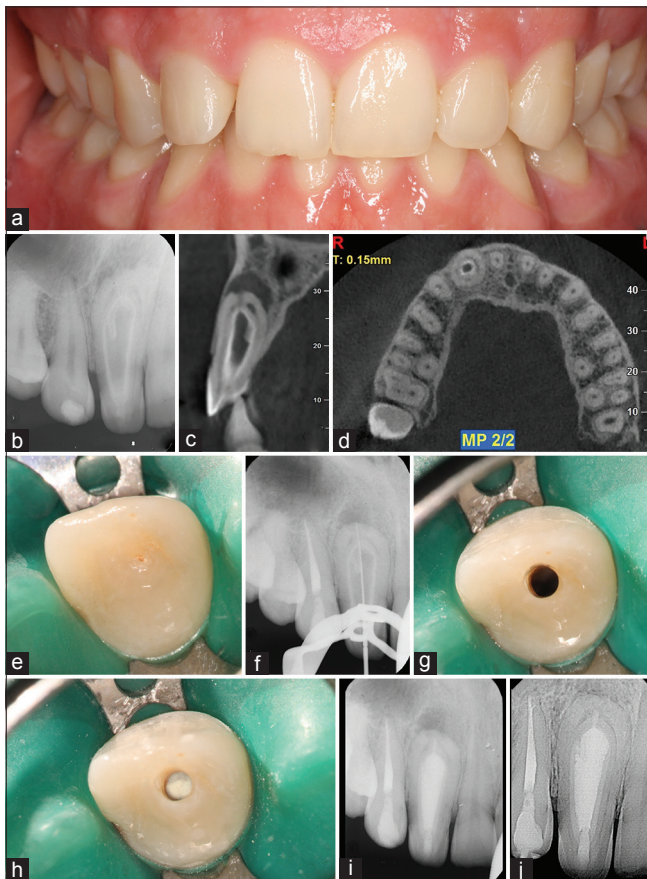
Treatment of tooth #7 (a) preoperative photograph (b) preoperative periapical radiograph, (c) preoperative cone-beam computed tomography sagittal slice showing a complete communication between the invagination and the periodontal tissues, (d) preoperative cone-beam computed tomography apical third axial slice, the ring shaped pulp system can be observed surrounding the invagination, (e) foramen coecum, (f) working length determination, (g) conservative access made to avoid violating the main pulp space, (h) MTA root canal obturation (i) postoperative radiograph, (j) 19 months recall (Case performed by JM)
